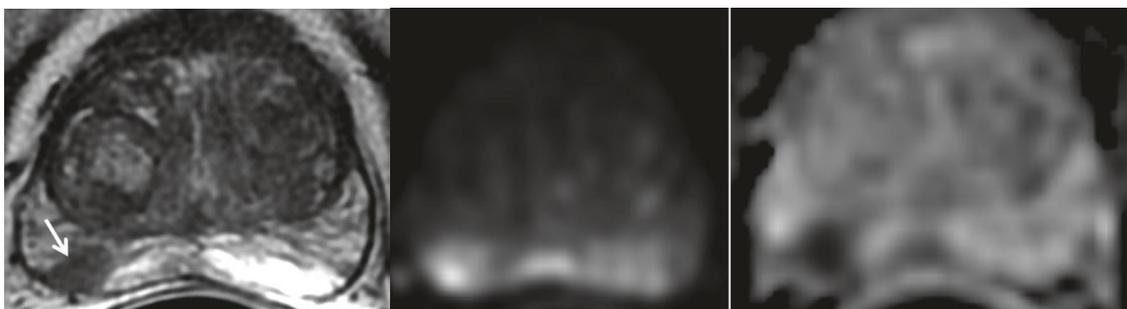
PI-RADS 4 category in PZ. First, axial T2WI. Second, b1400 DWI. Third, ADC map. Shows focal low signal lesion in the right PZ (arrow) on T2WI, with markedly hyperintense signal on DWI and markedly hypointense signal on ADC, <1.5 cm. Obtained from (12).
